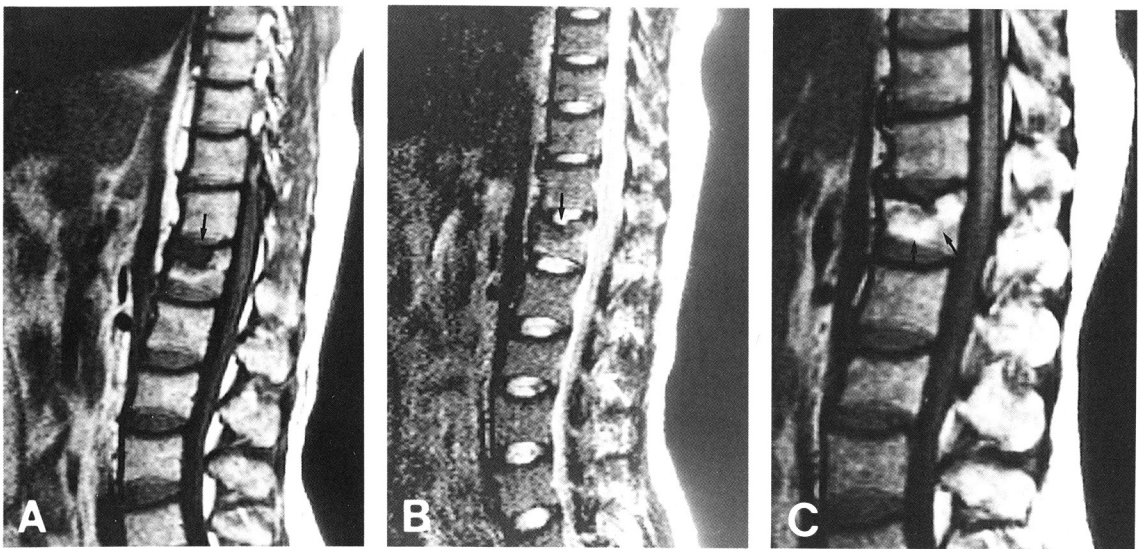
Types II and III compression fractures in a 38-year-old man. A, B, T1- and T2-weighted MR images obtained 5 months after a motor vehicle accident, demonstrate focal hypointensity (arrow) in the fractured T12 vertebral body (Type II). C, Follow-up MR image 2 years after trauma shows hyperintensity (arrows) on T1-weighted image and isointensity on T2-weighted image (not shown), representing type III fracture.
